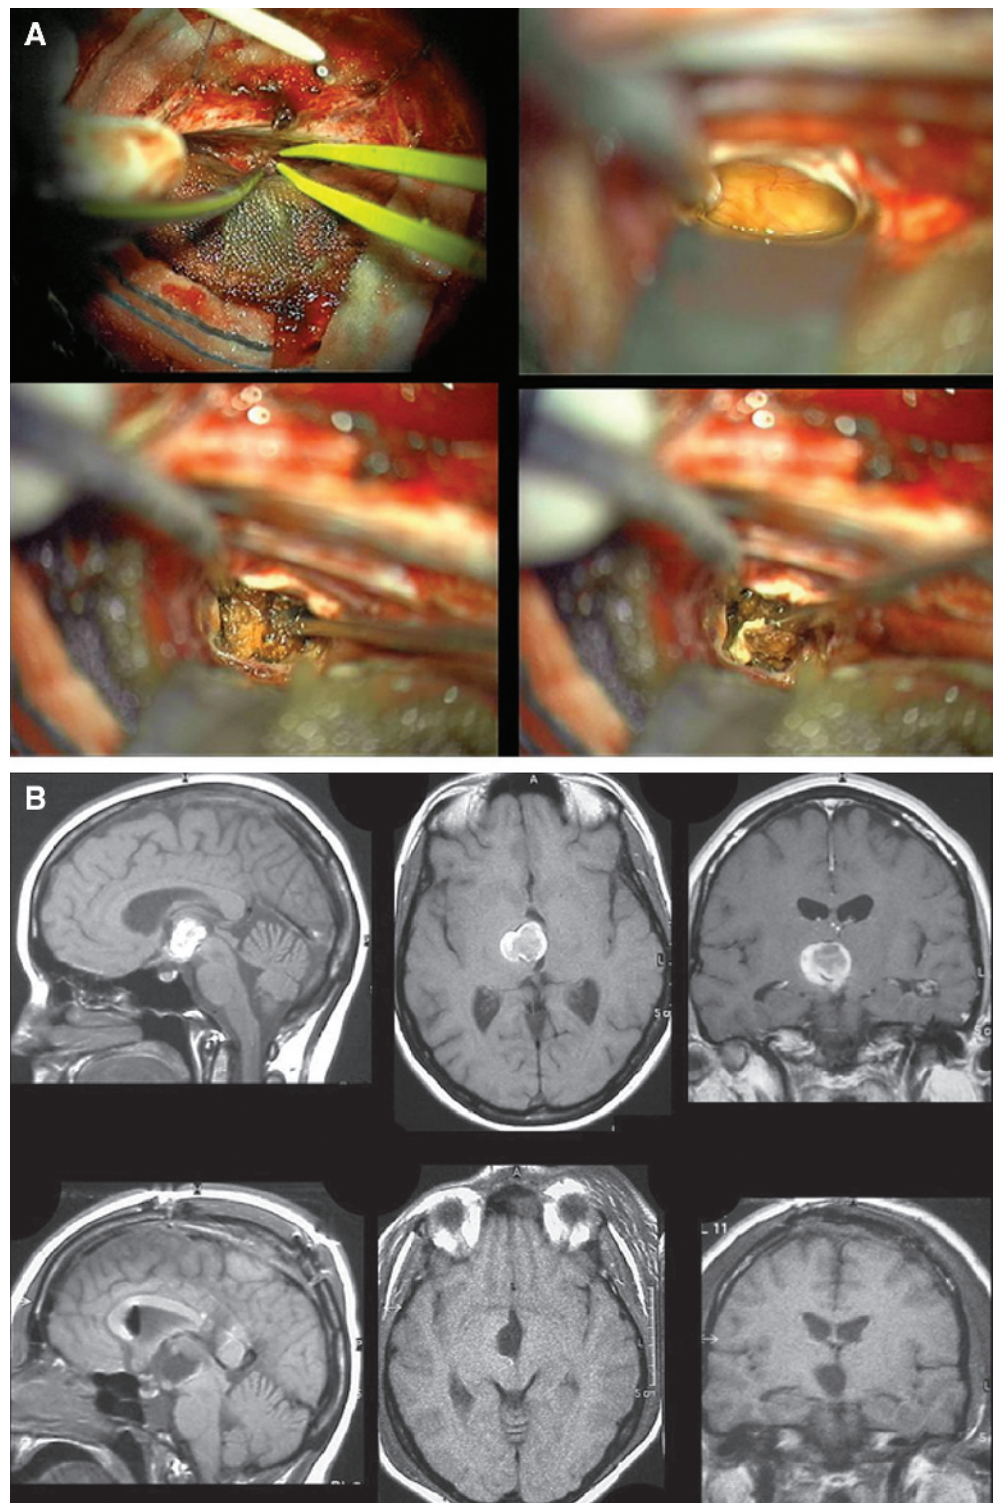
A, intraoperative photographs from transcallosal resection of cavernous malformation of the thalamus and upper brainstem. Top left, the patient is positioned with the head lateral to the floor with the right side down so that gravity assists in allowing the right hemisphere to fall away from the falx. Top right, after the corpus callosum is opened, the discolored thalamus is identified. Bottom, piecemeal resection and removal of malformation. B, top, preoperative MRI showing cavernous malformation of the thalamus and upper brainstem. Bottom, postoperative MRI documenting complete resection of the malformation.
